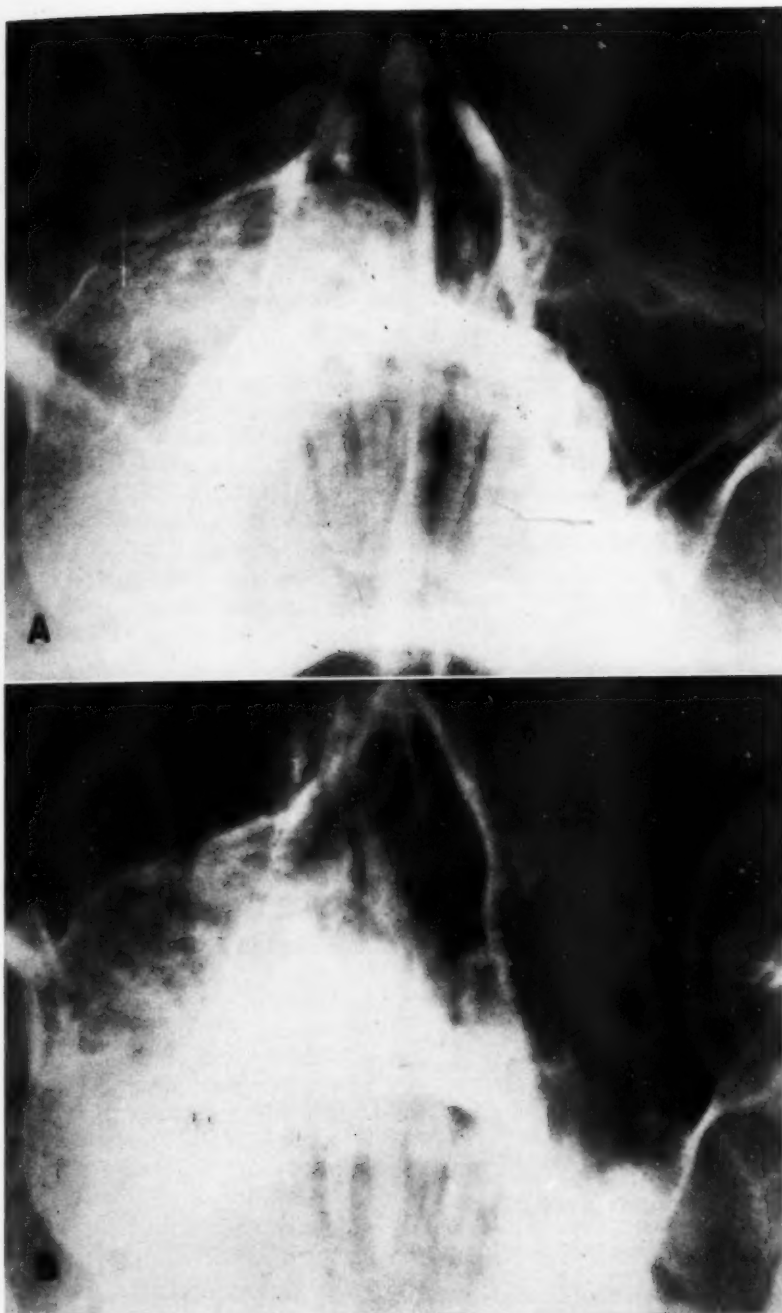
Case 11. A. Six years after initial symptoms this ossifying fibroma shows increased density. This represents an older tumor. B. Four years later only slight increase in size and greatly increased calcification are seen. These findings may be due to previous x-ray treatment.
